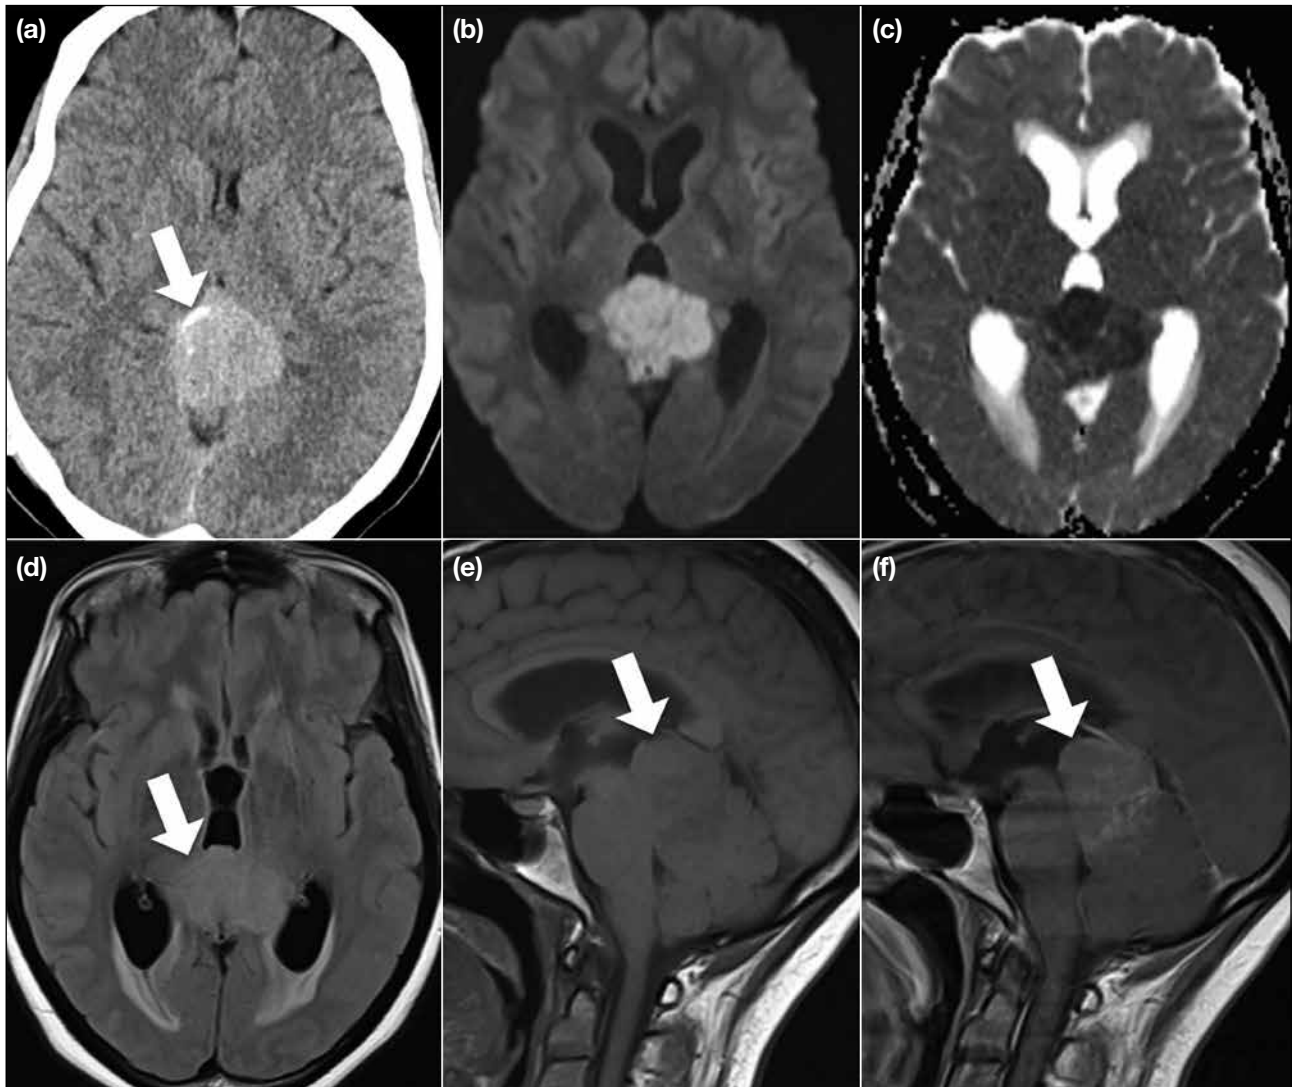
Primitive neuroectodermal tumour. The tumour is hyperdense on nonenhanced axial computed tomography image with displacement of the pineal calcification (arrow) from the midline by the tumour (a). Water restriction is noted on diffusion-weighted imaging (b) and apparent diffusion coefficient (c) images. The tumour (arrows) is iso- to hyperintense on axial T2-weighted fluid-attenuated inversion recovery image (d) and heterogeneously hypointense with heterogeneous enhancement on sagittal T1-weighted images (e and f).
